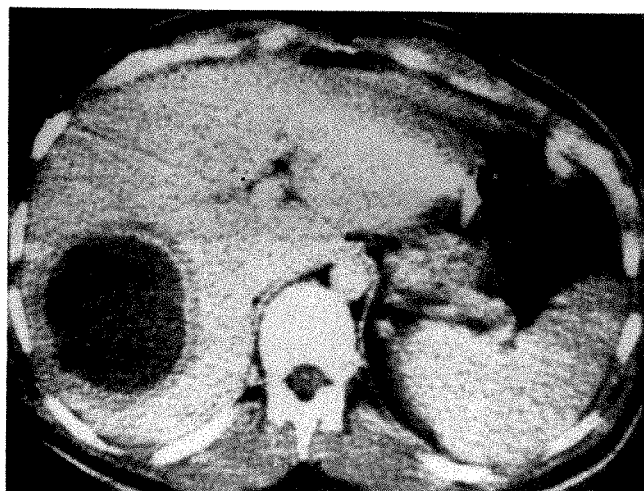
29-year-old man (recently returned from El Salvador) with fever, chills, and right upper quadrant pain. CT scan after intravenous administration of 75 ml of Conray 400 showing discrete filling defect 8 cm in diameter in right lobe of liver demarcated against enhanced normal liver parenchyma. Note thin intermediate zone of radiodensity surrounding filling defect, probably due to edema. At operation, amebic abscess was drained.
